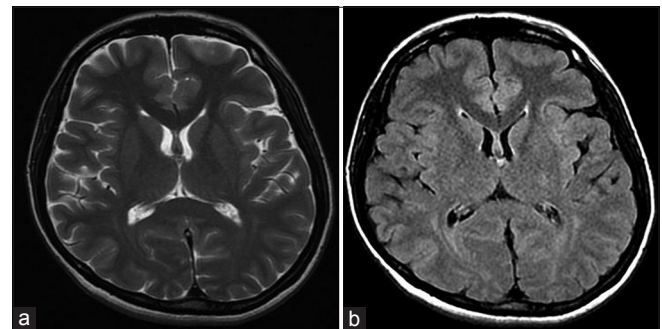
T2-weighted axial (a) and axial fluid-attenuated inversion recovery (b) images showing significant regression of the colloid cyst at 11 months follow-up from the time of initial diagnosis
